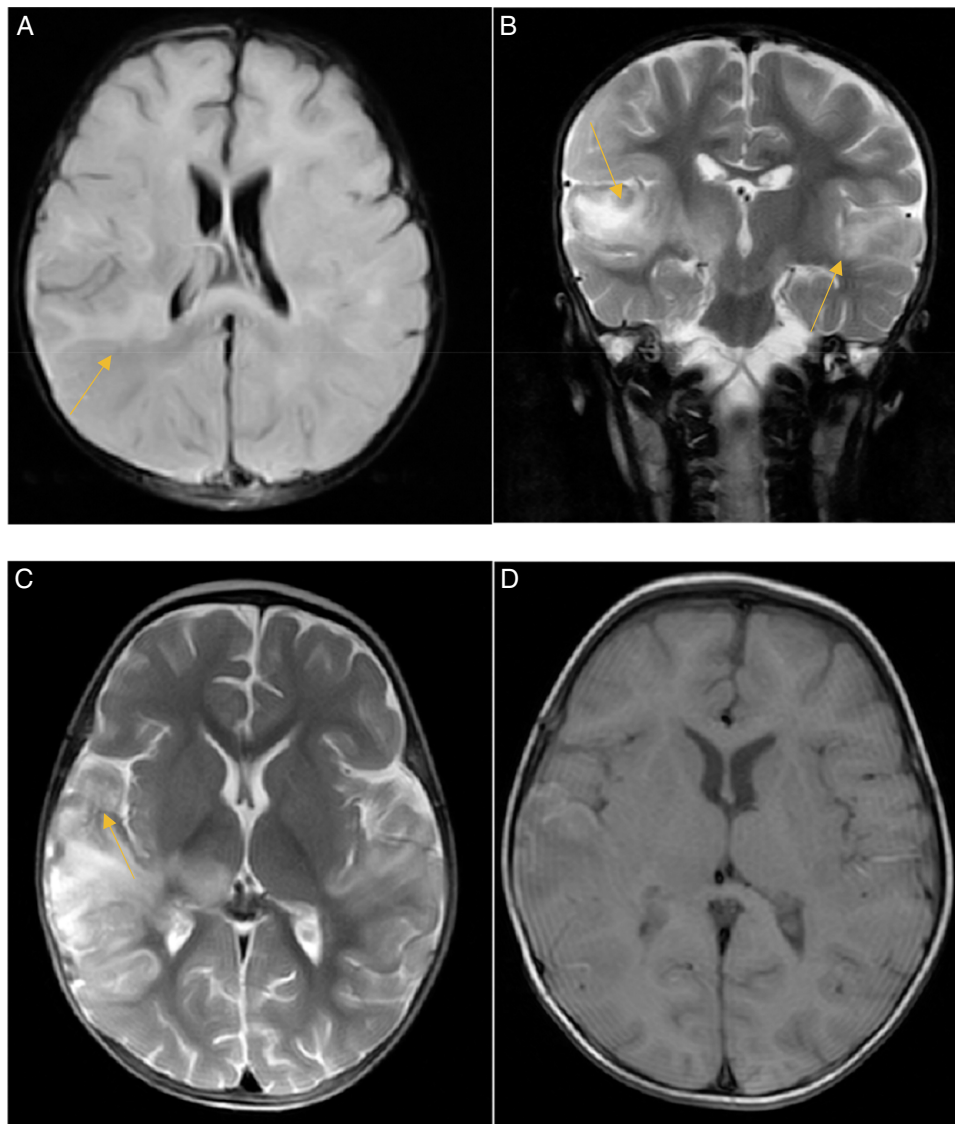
MRI findings. (A) Increased signal on right temporoparietal region in FLAIR sequence in axial section. (B) Increased signal on right and left temporoparietal region with right side predominance in coronal section on T2WI. A “ribbon-like sign” on a brain MRI refers to a radiological finding where there is a linear or ribbon-shaped area of abnormal signal intensity in the brain, typically seen on T2-weighted or FLAIR sequences. This finding can be associated with various conditions such as demyelinating diseases (e.g. multiple sclerosis), inflammatory disorders, infections like herpes simplex encephalitis (HSV) or certain neurodegenerative conditions. The appearance of a ribbon-like sign can provide important diagnostic information to help guide further evaluation and treatment. Based on the clinical presentation of the patient and the findings in the cerebrospinal fluid, our diagnosis was herpes encephalitis. (C) Increased signal on right temporoparietal region in axial section on T2WI. (D) Increased signal on right temporoparietal region in sagittal section on T2WI.
